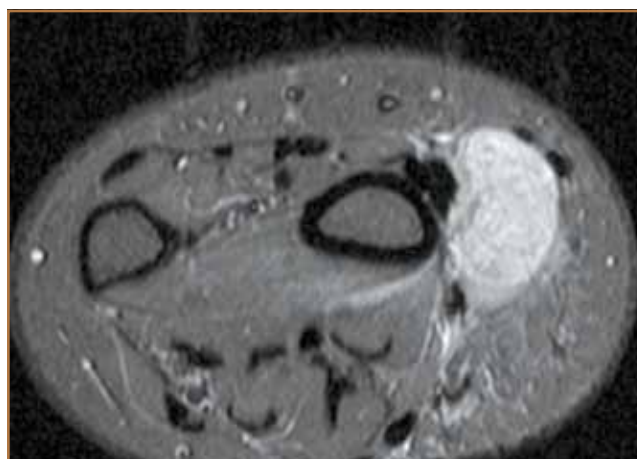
Axial T2-weighted magnetic resonance imaging of wrist mass that proved to be a sarcoma.
